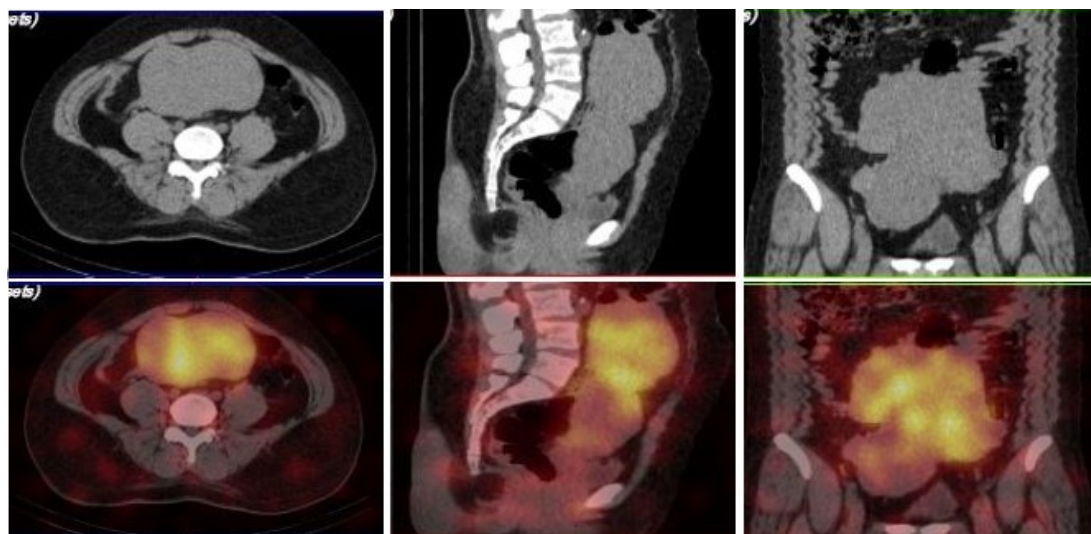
SPECT/CT scan was performed to evaluate the radioiodine uptake in the pelvis. Transaxial, sagittal, and coronal slices of the CT scan (upper row) and the corresponding I-131 SPECT/CT fusion images (lower row) are presented. The SPECT/CT scan revealed that the I-131 uptake was associated with multiple uterine myomas compatible with MRI findings
